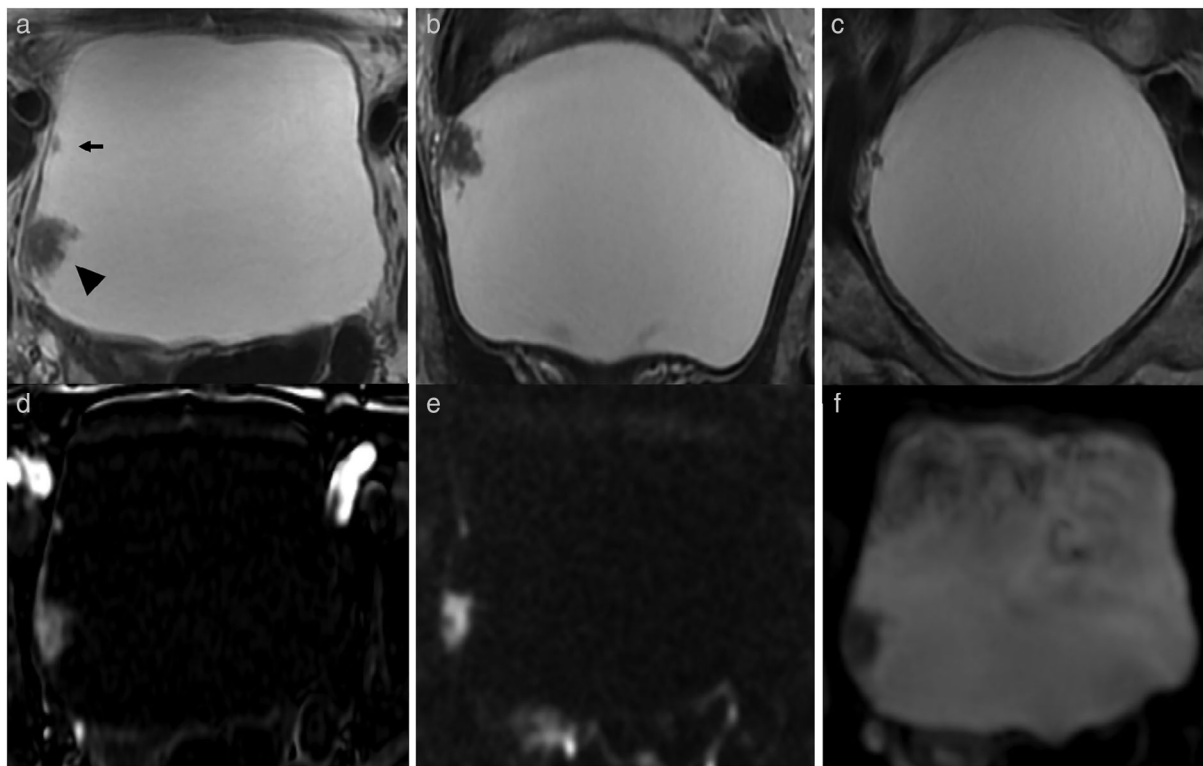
A 64-year-old female with positive cystoscopy. (a–c) T₂W imaging (axial, coronal plane) shows two pedunculated masses, one <1 cm in size (arrow) and one >1 cm in size (arrowhead), both in the right lateral bladder wall, the smaller localized more anteriorly, both with intermediate SI not extending through the muscularis propria. T₂W imaging assigned as VIRADS categories 1 and 2, respectively. (d) DCE imaging shows early and heterogeneous enhancement of the lesions, not extending through the muscularis propria; enhancement of the inner layer can be appreciated. DCE assigned as VI-RADS categories 1 and 2, respectively. (e,f) DWI (b = 2000) and ADC maps show significant restricted diffusion, not extending through the muscularis propria; the inchworm sign can be appreciated at the posterior lesion. DWI assigned as VIRADS categories 2 and 1, respectively. Overall VI-RADS score was 1 for the smaller mass and 2 for the larger.
